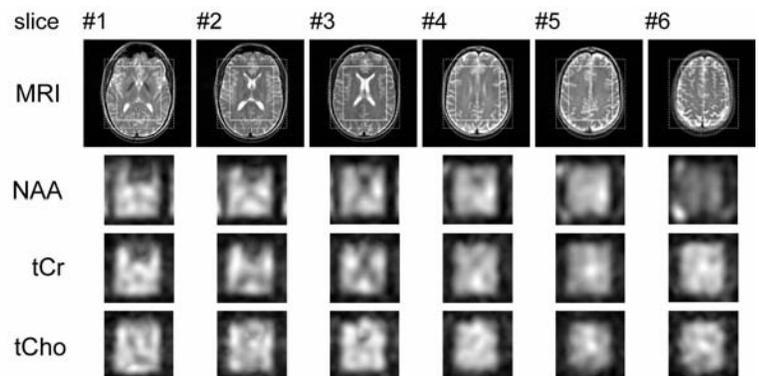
Metabolic images (NAA, tCr and tCho) of the excited six slices and corresponding MRI images; FOV (dotted line) and VOI (solid line) marked in MRI images
